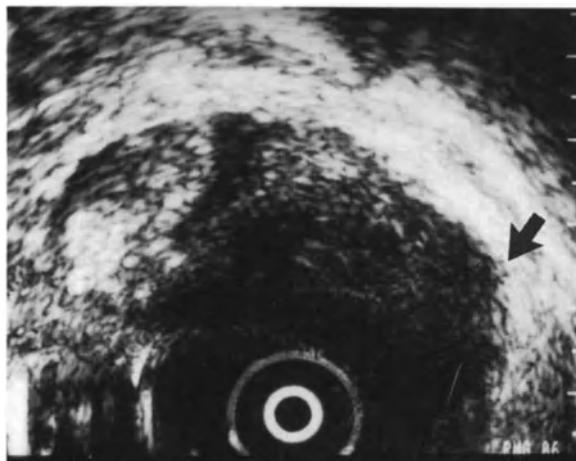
Transrectal sagittal ultrasound of the prostate. There is an irregular echo-poor lesion in the peripheral zone of the gland (*arrow*). *S*, symphysis.
